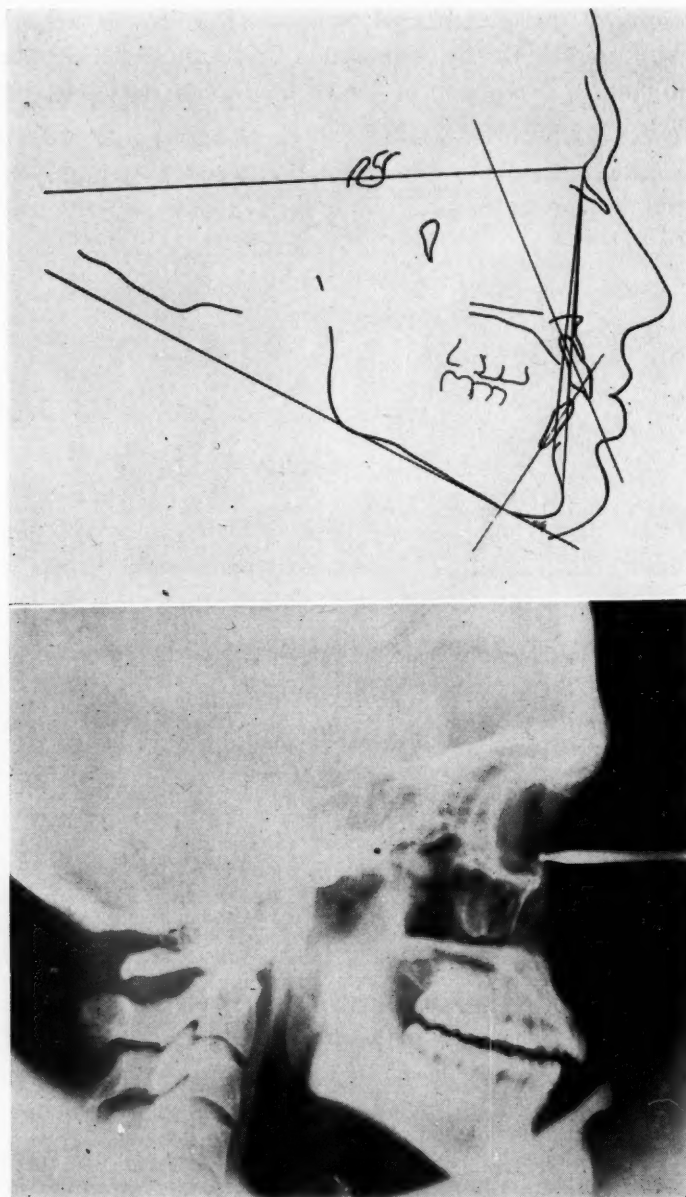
Patient W. S. Cephalometric radiograph and tracing in approximate physiologic rest.
